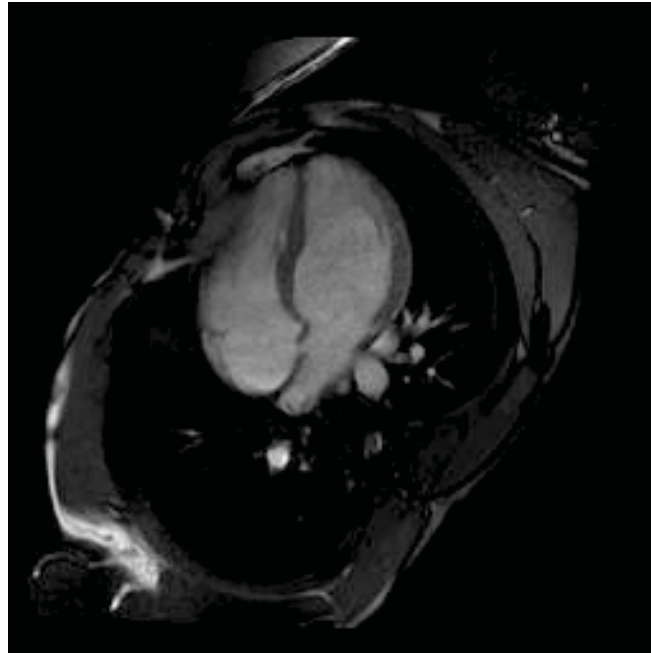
Preoperative MRI showing residual shunt
